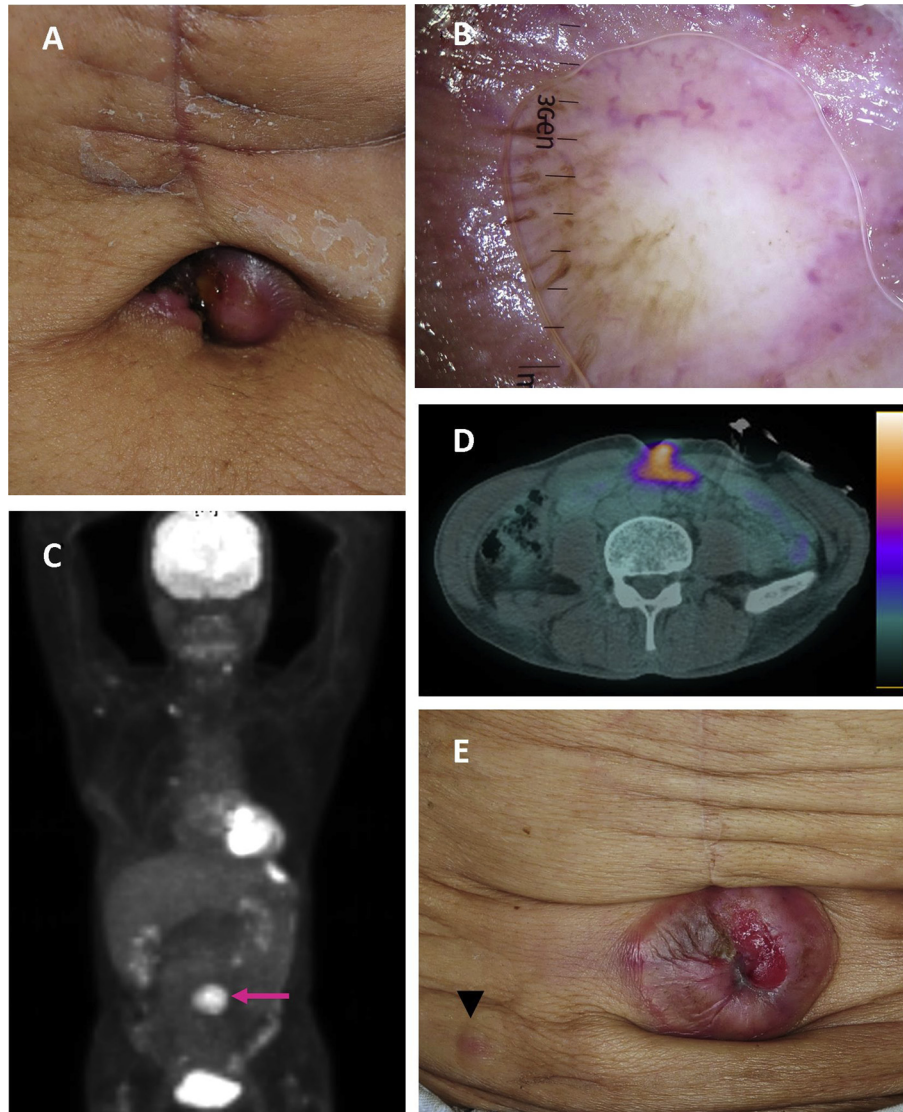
Features of the Sister Mary Joseph nodule. (A) The nodule appears as an erythematous and indurated nodule over the umbilicus. (B) The dermoscopic examination reveals a white veil, and serpentine, dotted, and comma-shaped vessels. Direct compression by the dermoscope causes blanching of the nodule. (C) The pink arrow indicates a hypermetabolic SMJN from the anterior view on whole-body positron emission tomography. (D) Positron emission tomography/computed tomography imaging shows prominent glucose hypermetabolic signals over the periumbilical area and the abdominal cavity. The gradient color bar on the right side of the photograph is a reference for glucose metabolic activity. (E) Six months later, the nodule has enlarged and occupies the whole umbilicus. The arrow head indicates another possible cutaneous metastasis. SMJN = Sister Mary Joseph nodule.
